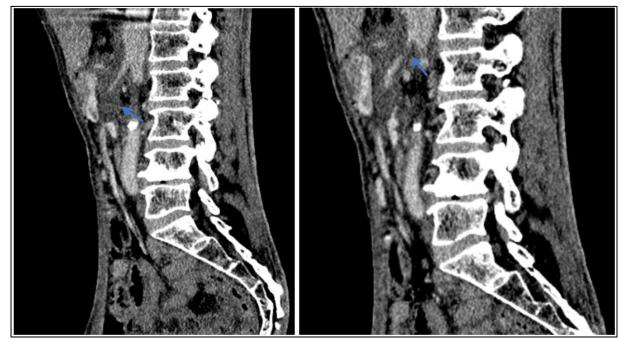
Sagittal images of abdominal CT with contrast showing a hypodense a circumferential mass (arrow) surrounding the abdominal sus renal aorta and its visceral branches, extending into the peritoneum following the path of the superior mesenteric artery
